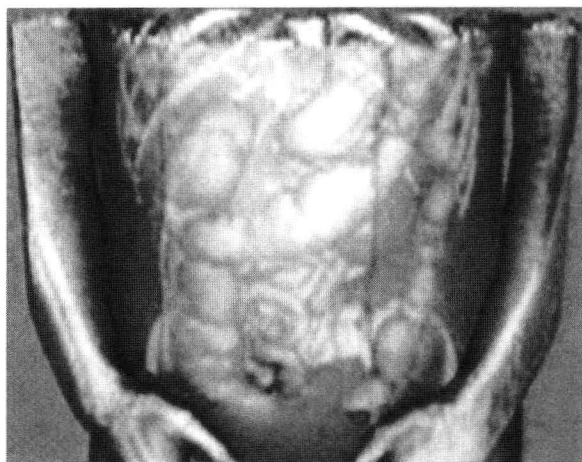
The images, obtained by spiral CT scan of the same patient are treated by computer subtraction of elements to visualize the internal organs. *Source:* Courtesy of J. Marescaux IRCAD/EITS University of Strasbourg, France.
